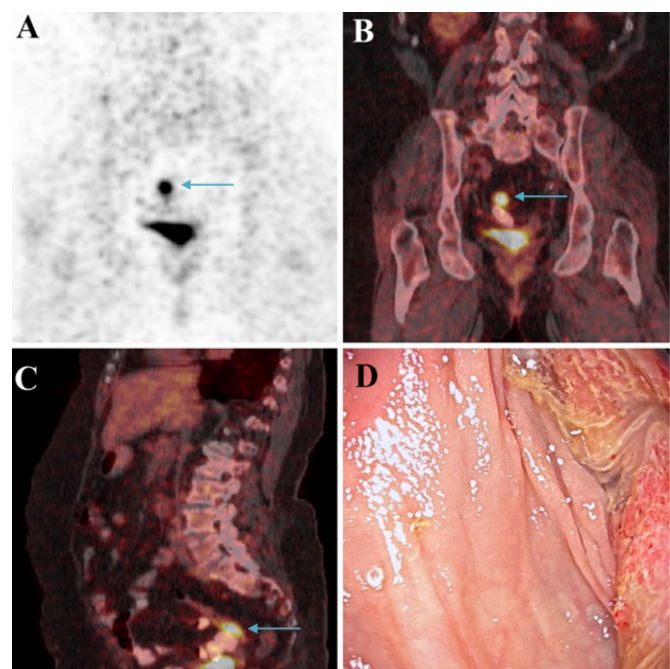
A 72-year-old female patient undergoing 18F-FDG PET/CT for skin cancer staging (A-C) (blue arrows). Abnormal 18F-FDG PET/CT uptake in the sigmoid colon (SUVmax: 18.01). (D) Colonoscopy revealed a mass in the sigmoid colon, and the pathological diagnosis confirmed adenocarcinoma
